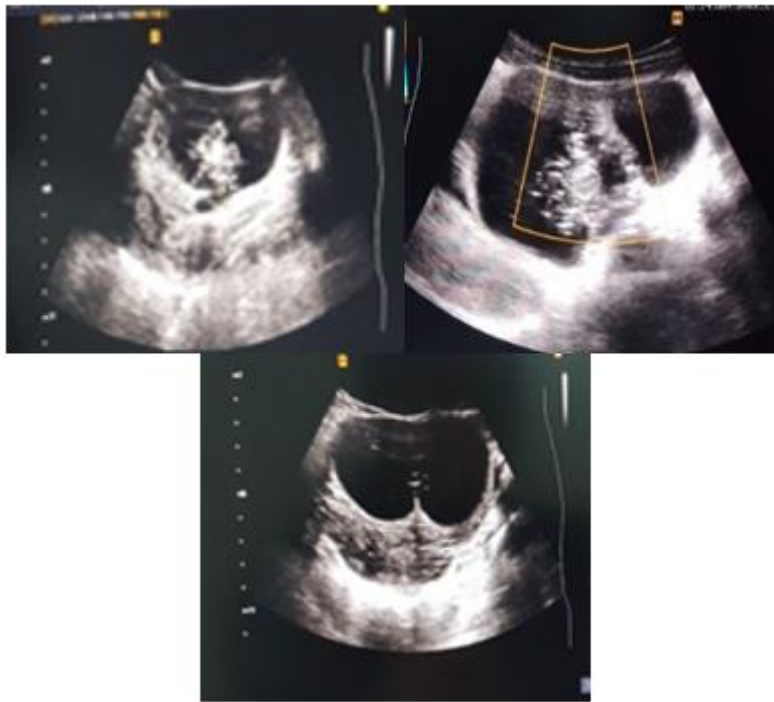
Ultrasound examination revealed large, heavy cysts (the string of pearls sign) and cystic teratomas. An enlarged, hemorrhagic, torted right ovary and Doppler imaging showing outside flow with negative center.
